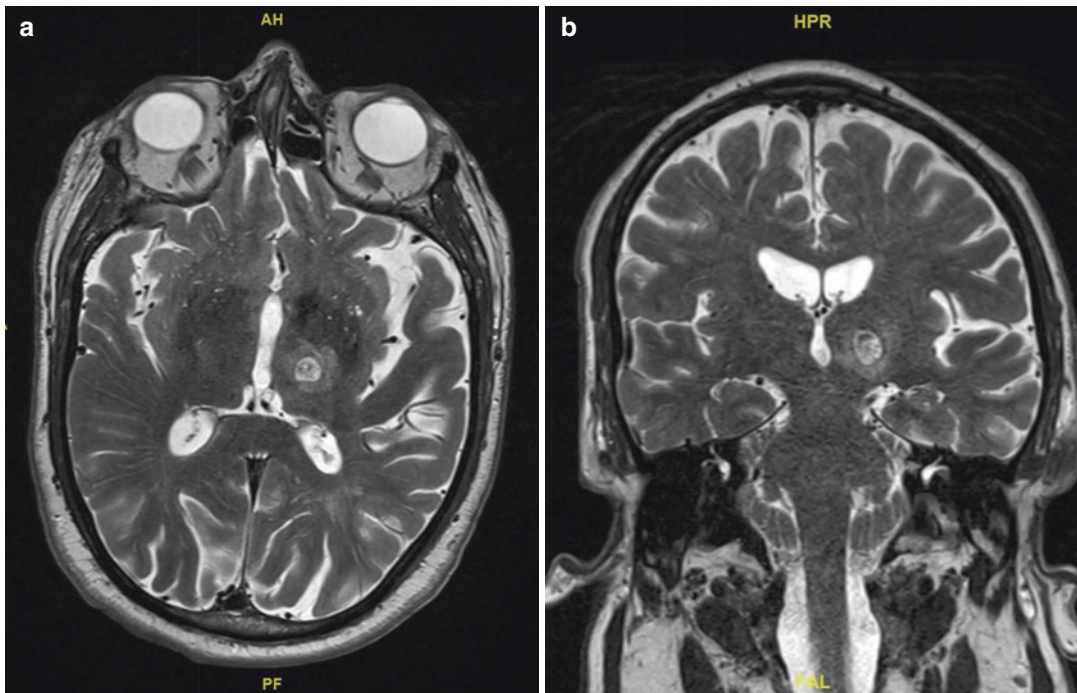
Axial (a) and coronal (b) thin cut T2-weighted MR images 24 hours post-FUS thalamotomy
